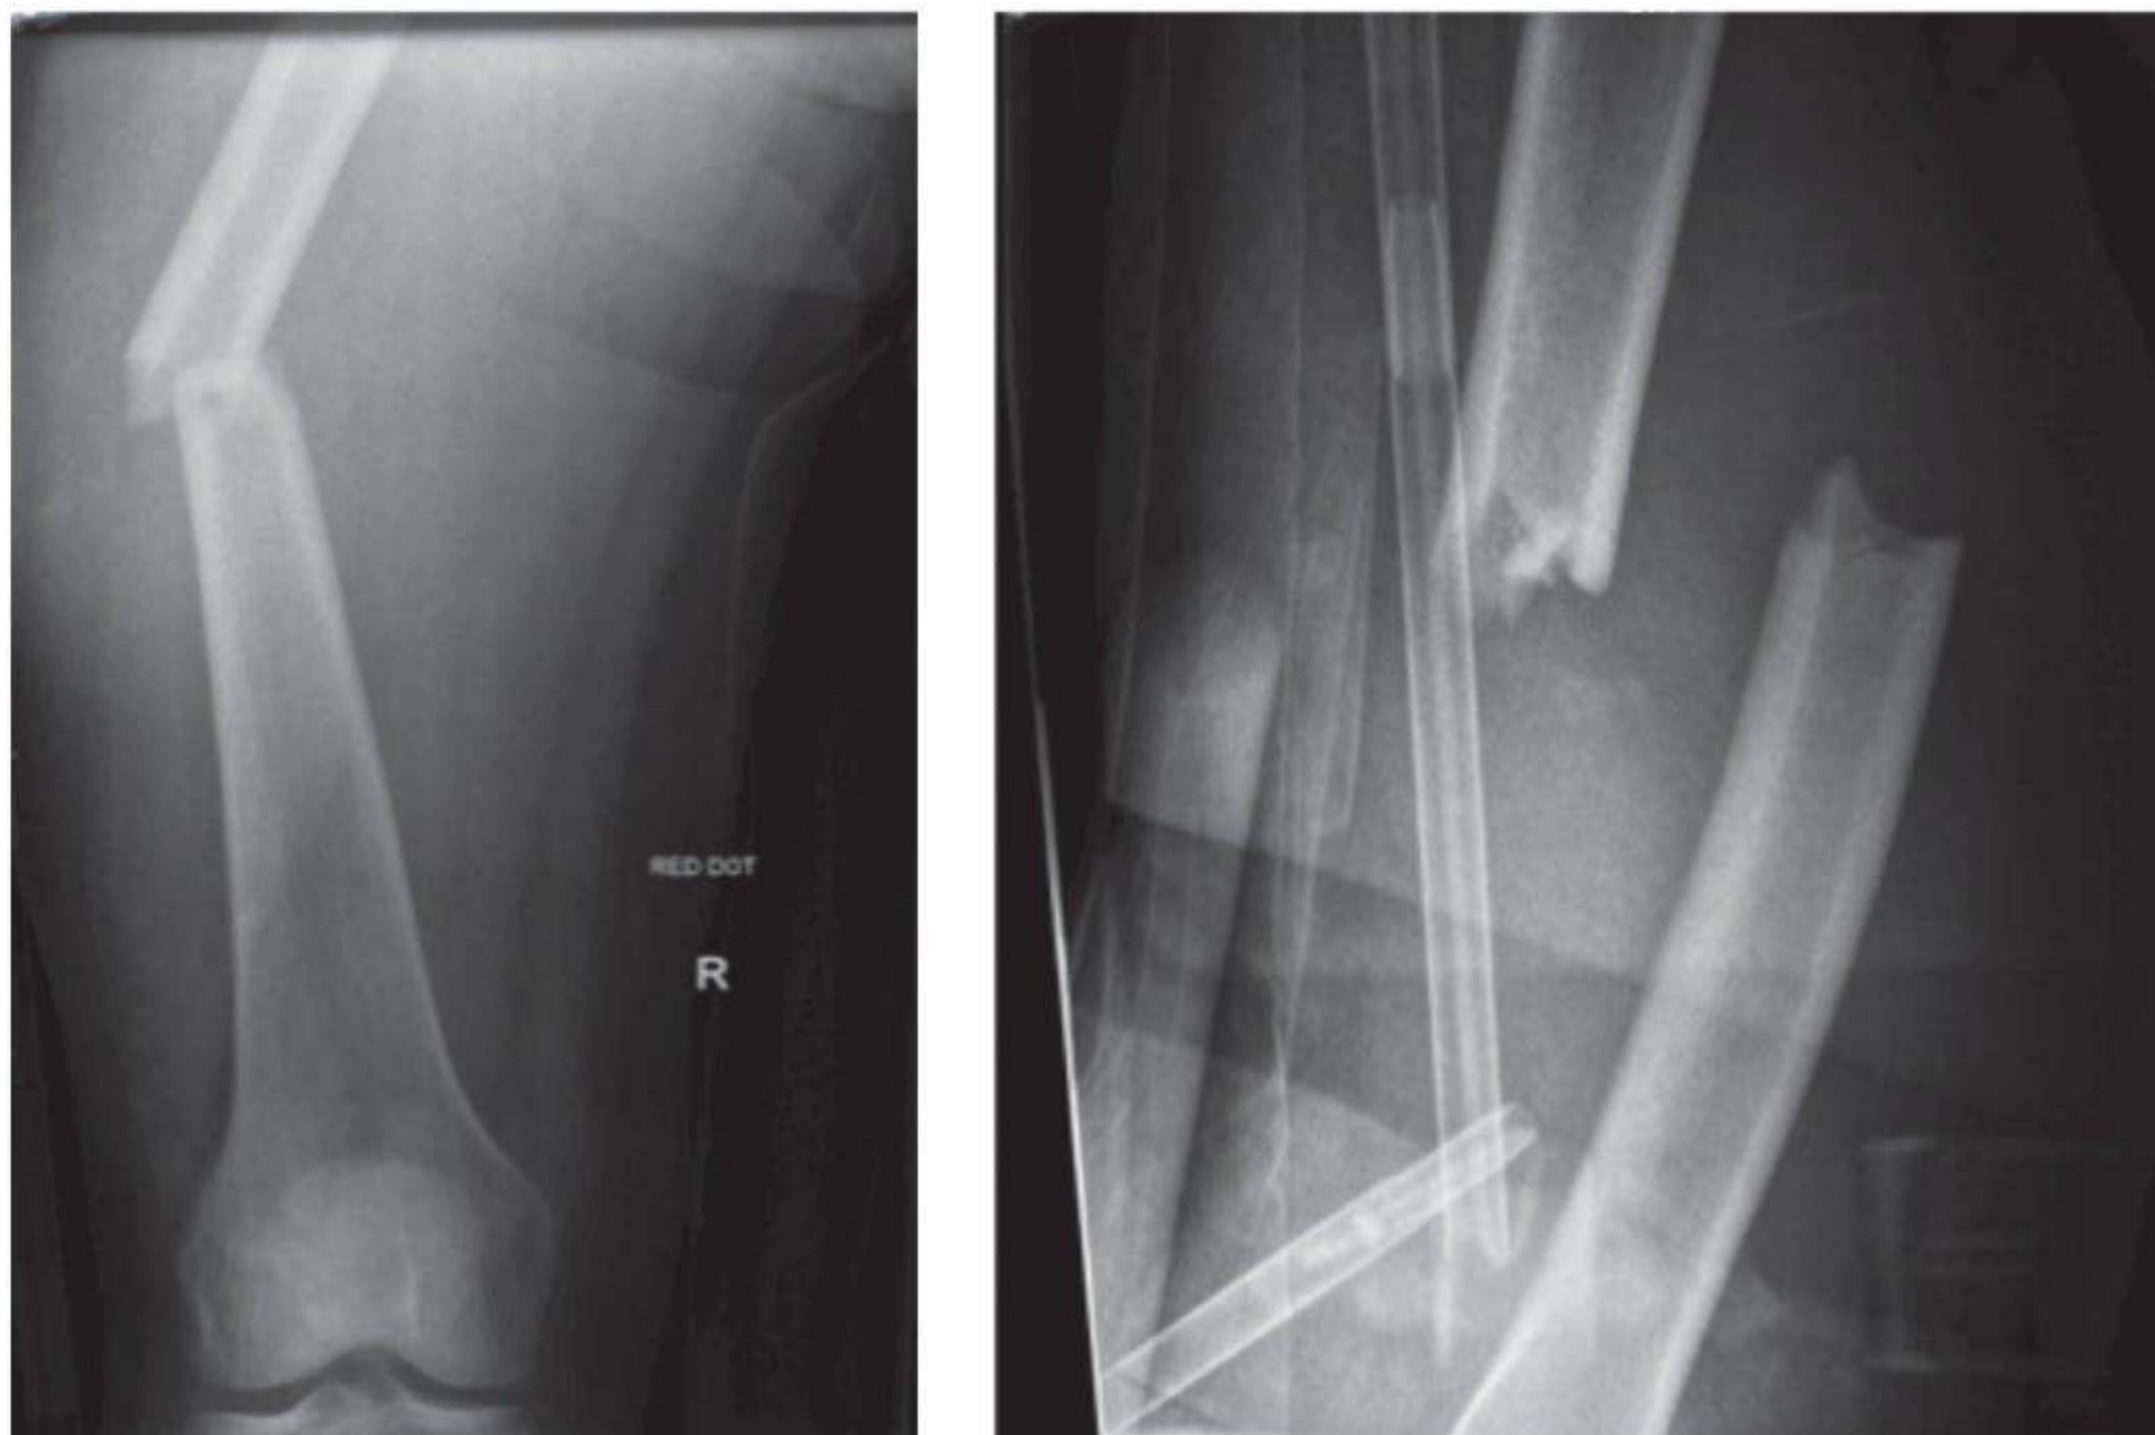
Femoral radiographs
